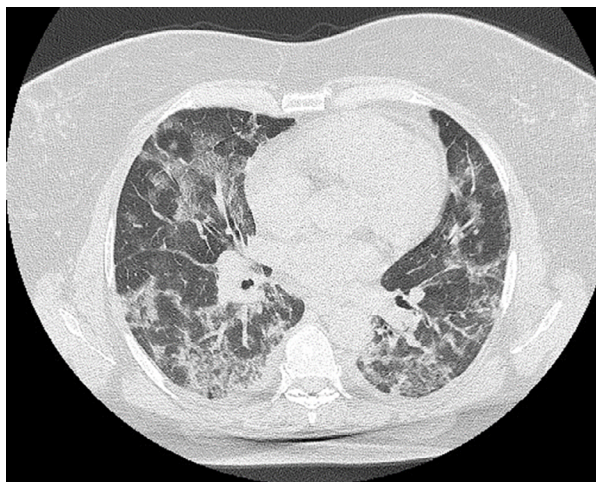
Example of typical CT imaging features for severe COVID-19 in 65-year-old male patient (during hospitalization) showing bilateral multifocal crazy paving pattern, ground-glass opacities, and posterior consolidation on the right side.
